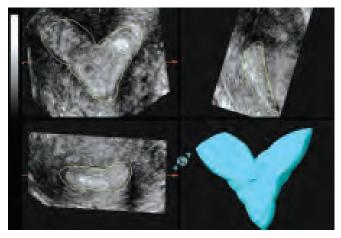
Three-dimensional ultrasound of a septate uterus. Note partial division of the uterine cavity and "Y" shape of the uterine cavity. Hysteroscopy confirmed subseptate uterus
